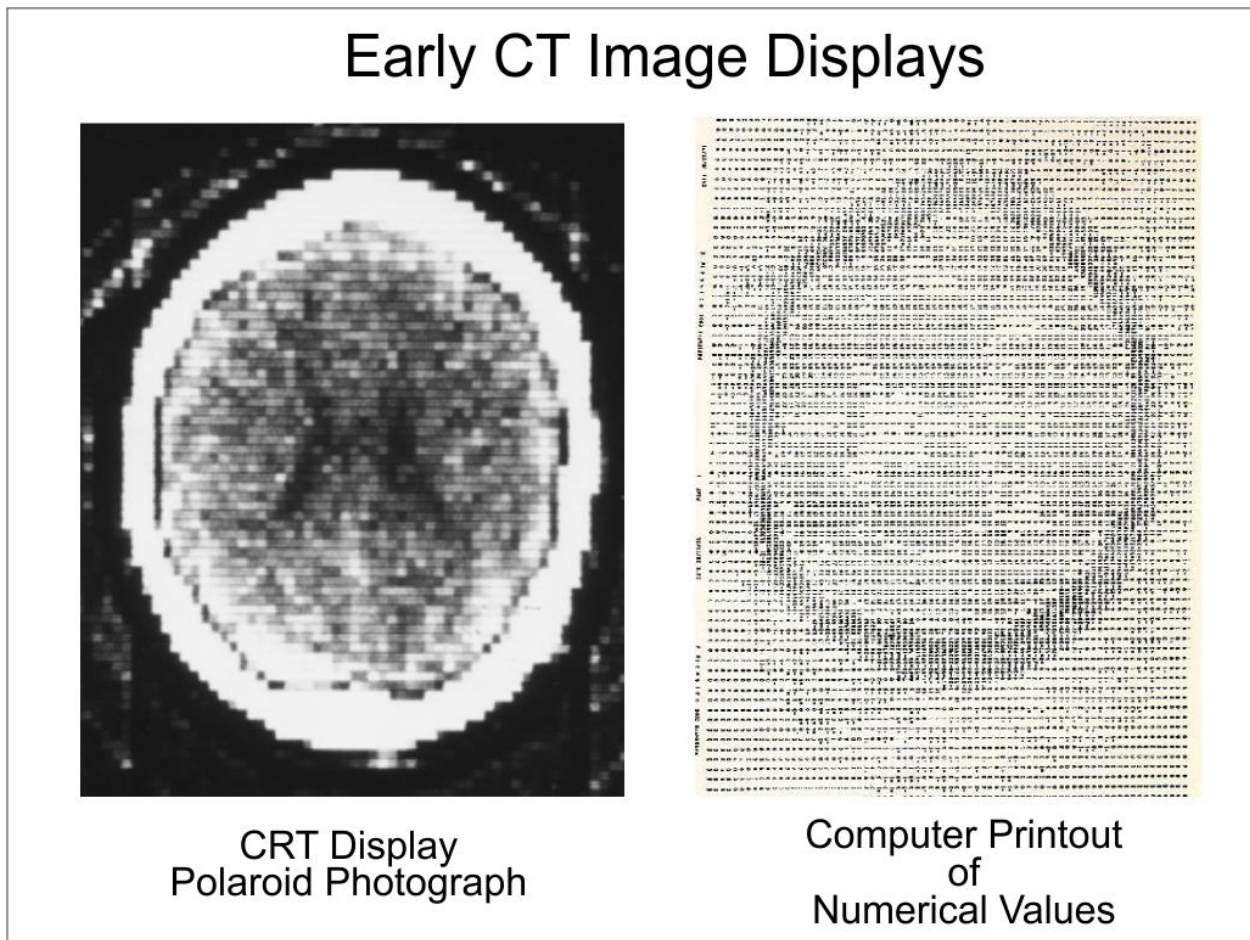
The two types of image displays for the first CT scanners.
